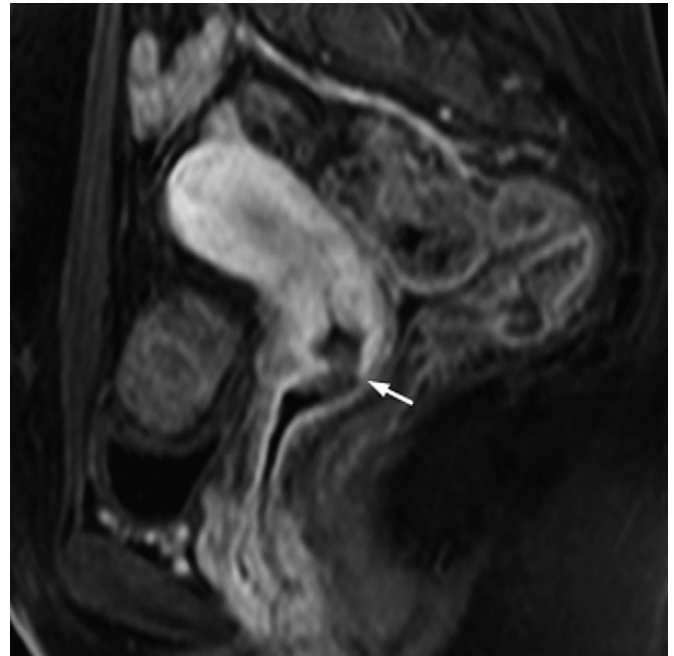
Sagittal contrast-enhanced fat-saturated 3D T1-weighted magnetic resonance images of the pelvis. A polypoid mass (arrow) is seen within the internal os of the left-sided cervix. The mass can be seen protruding into the upper vagina, and invading the anterior vaginal mucosa.
